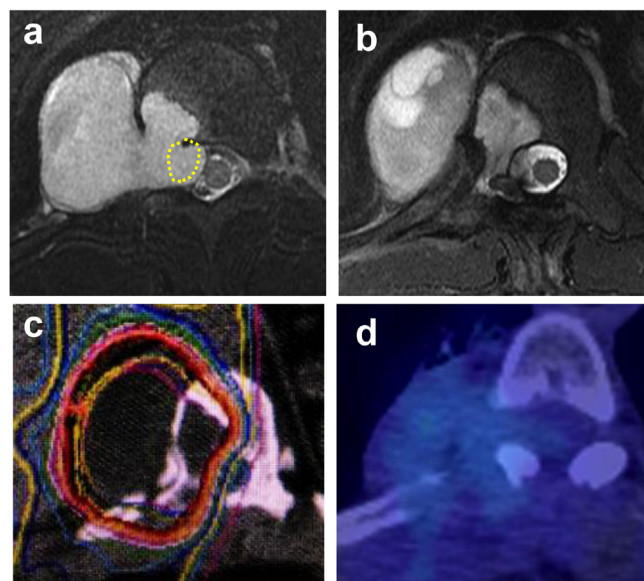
Carbon-ion radiotherapy surgical support (CIRT-SS) for primary malignant spinal cord tumors. (a) A 49-year-old male with T11/12 malignant peripheral nerve sheath tumor causing dural compression (dashed lines). (b) Decompression of the dura mater by separation surgery (excision of dashed lines). (c) CIRT-SS enabling sufficient irradiation dose to the entire tumor (red line indicates 90% dose). (d) Post-operative PET-CT axial image. FDG uptake of the tumor is not shown.
